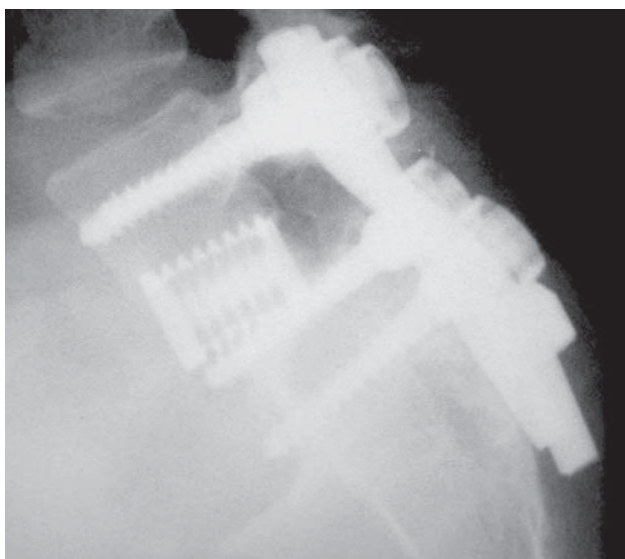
Patient 1. Postoperative imaging. Lateral radiograph demonstrates solid instrumented L5-S1 circumferential fusion.
